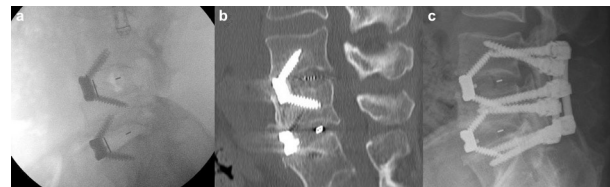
Patient requiring a reoperation with the placement of posterior instrumentation for recurrence of radiculopathy after implant subsidence. (A) Intraoperative radiograph showing good position of L4-5 and L5-S1 implants. (B) Computed tomography scan obtained after recurrence of L4 radiculopathy showing subsidence of L4-5 implant into the superior endplate of L4. (C) Postoperative radiograph showing placement of posterior instrumentation for stabilization. The anterior lumbar interbody fusion implant was not revised.
